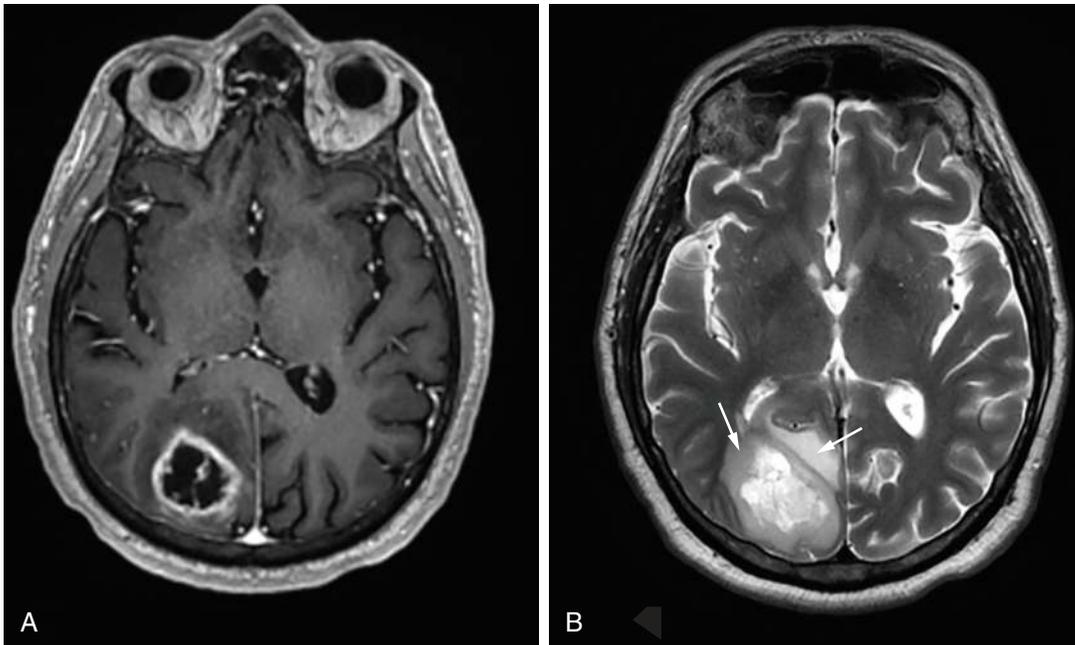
MRI appearance of high-grade glioma. A, T1-weighted MRI with contrast shows a peripherally enhancing intraaxial mass in the medial right occipital lobe. This mass was resected, and pathology returned glioblastoma (WHO grade IV). B, T2-weighted MRI shows extensive surrounding vasogenic edema. Vasogenic edema is commonly seen surrounding intraaxial brain tumors and results from disruption of the blood-brain barrier by the neoplastic process.
